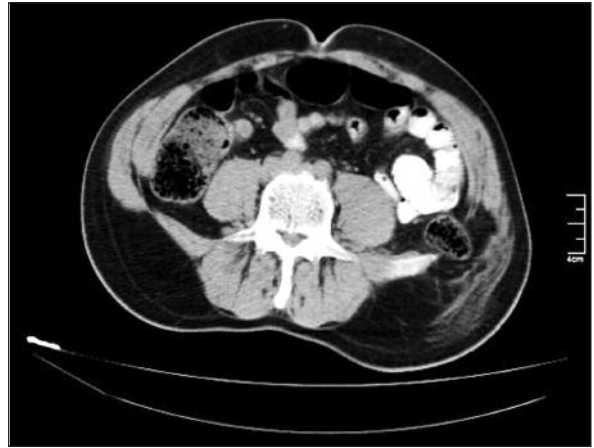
Computed tomography showed a colon segment herniated through the wall defect.
